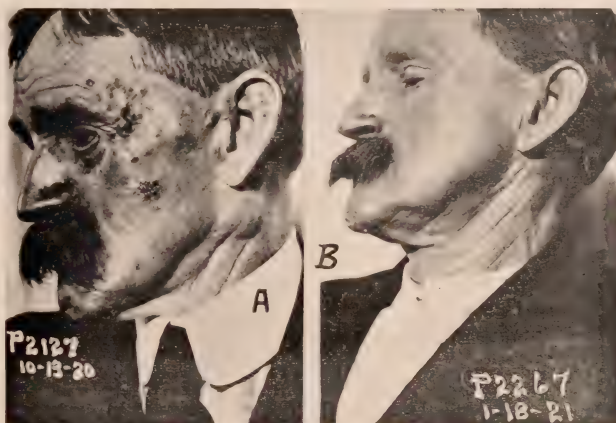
(a)—Dr. Harry Jarrett's patient. Epithelioma in the left temporal region and sides of the face with metastasis from the temporal lesion back of the angle of the jaw. Lesions on the face destroyed by electro-coagulation October 13, 1920, followed by x-ray treatment and eight ten-milligram needles inserted into the metastatic lymph node for five hours, October 12, 1920, and for six and one-half hours November 23, 1921. Figure V.—(b)—Shows complete disappearance of this lymph node January 18, 1921, together with disappearance of the other lesions on the face. There had been no recurrence of this lymph node November 14, 1921.
